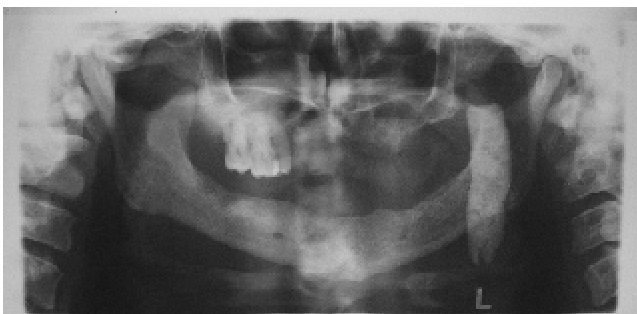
Orthopantomogram revealing a large calcified mass.
